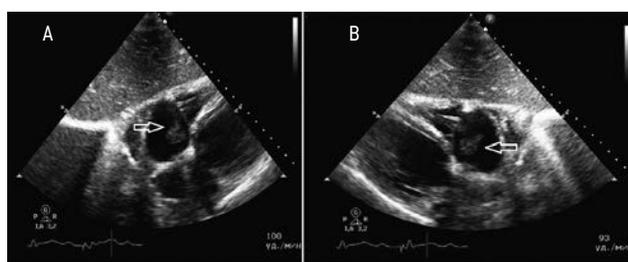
Echocardiogram of patient A., 04.2019 A — Four-chambered apical section; B — Three-chambered subcostal modified section. The arrows indicate a large loose vegetation located on the electrode near the TV structures.
